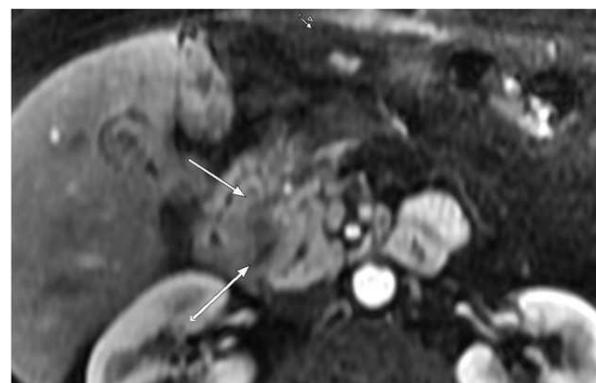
Contrast enhanced MRI of pancreatic adenocarcinoma (arrows) with the characteristic ill defined margins that render this type of cancer difficult to delineate.
